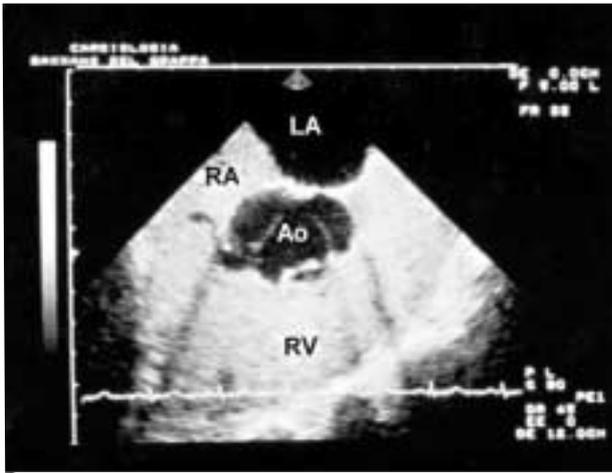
Contrast echocardiography shows right chamber opacification with a "minus effect" due to the ruptured sinus of Valsalva and the left-to-right shunt. LA = left atrium. Other abbreviations as in figures 1 and 2.
